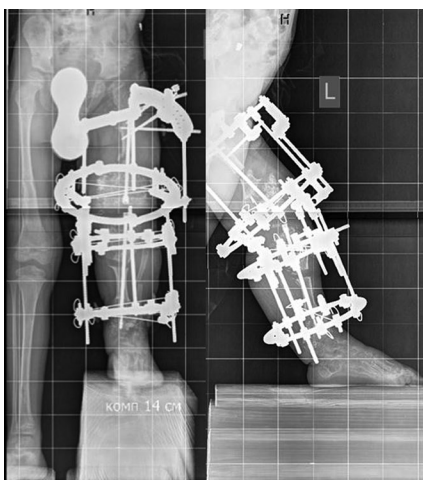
Radiographs taken after completion of combined osteosynthesis
